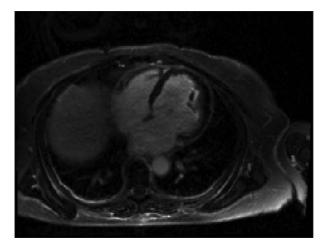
Comparative post contrast Magnetic Resonance Image showing endomyocardial enhancement with overlying low signal thrombus as well as pericardial enhancement.
